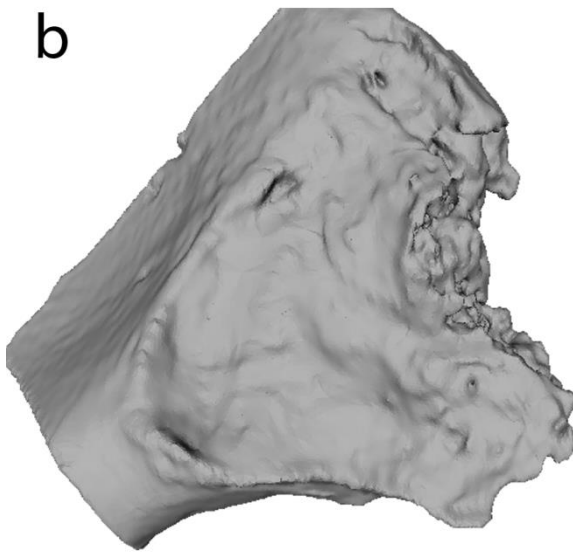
Photograph (a), 3D model from CT scans (b), 3D model from laser scan (c) of the same auricular surface. CT scans were performed using Siemens Somatom Sensation 4 at 120 kV,110
